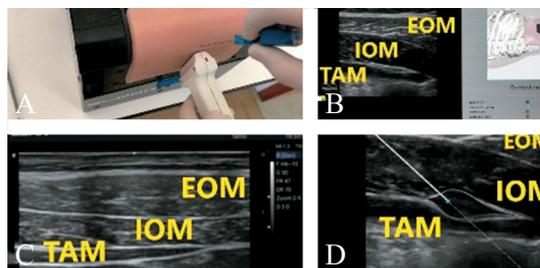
A) BlockSim™ with insert for practicing UGRA. B) Ultrasound image of BlockSim™ with target. C) Real ultrasound images of the abdominal wall is shown. D) Tap block of BlockSim™ with the needle on the target and opening of fascial plane. N: needle; EOM: external oblique muscle; IOM: internal oblique muscle; TAM: transversus abdomen muscle.
